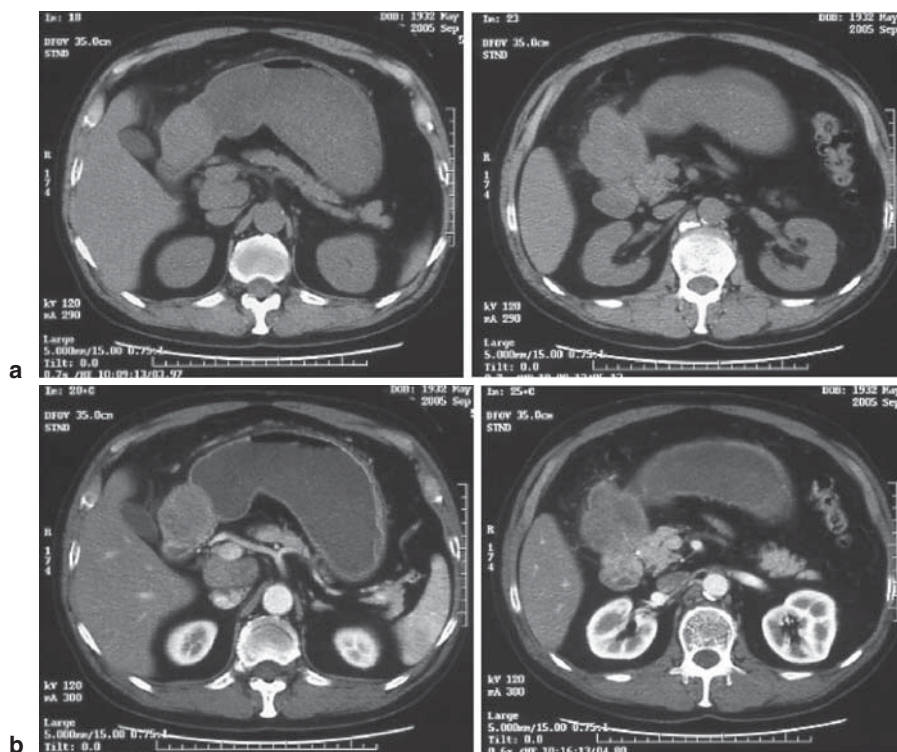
a Plain computed tomography (CT) showed two masses, one located around the pylorus and another between the portal vein and inferior vena cava. b Enhanced CT showed the mass to have a strong enhancement heterogeneously
